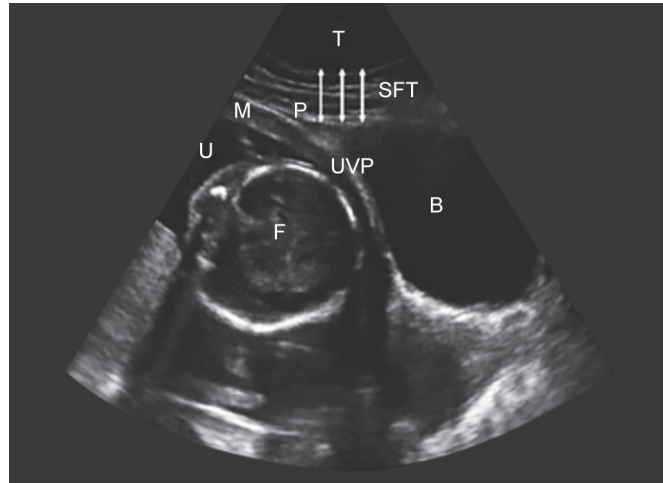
Ultrasound image of subcutaneous fat thickness measurement B, bladder; F, fetus; P, peritoneum lining the uterus; SFT, subcutaneous fat thickness taken from an average of three measurements 0.5 cm apart; T, transducer face; U, uterus; UVP, ureterovesical pouch
